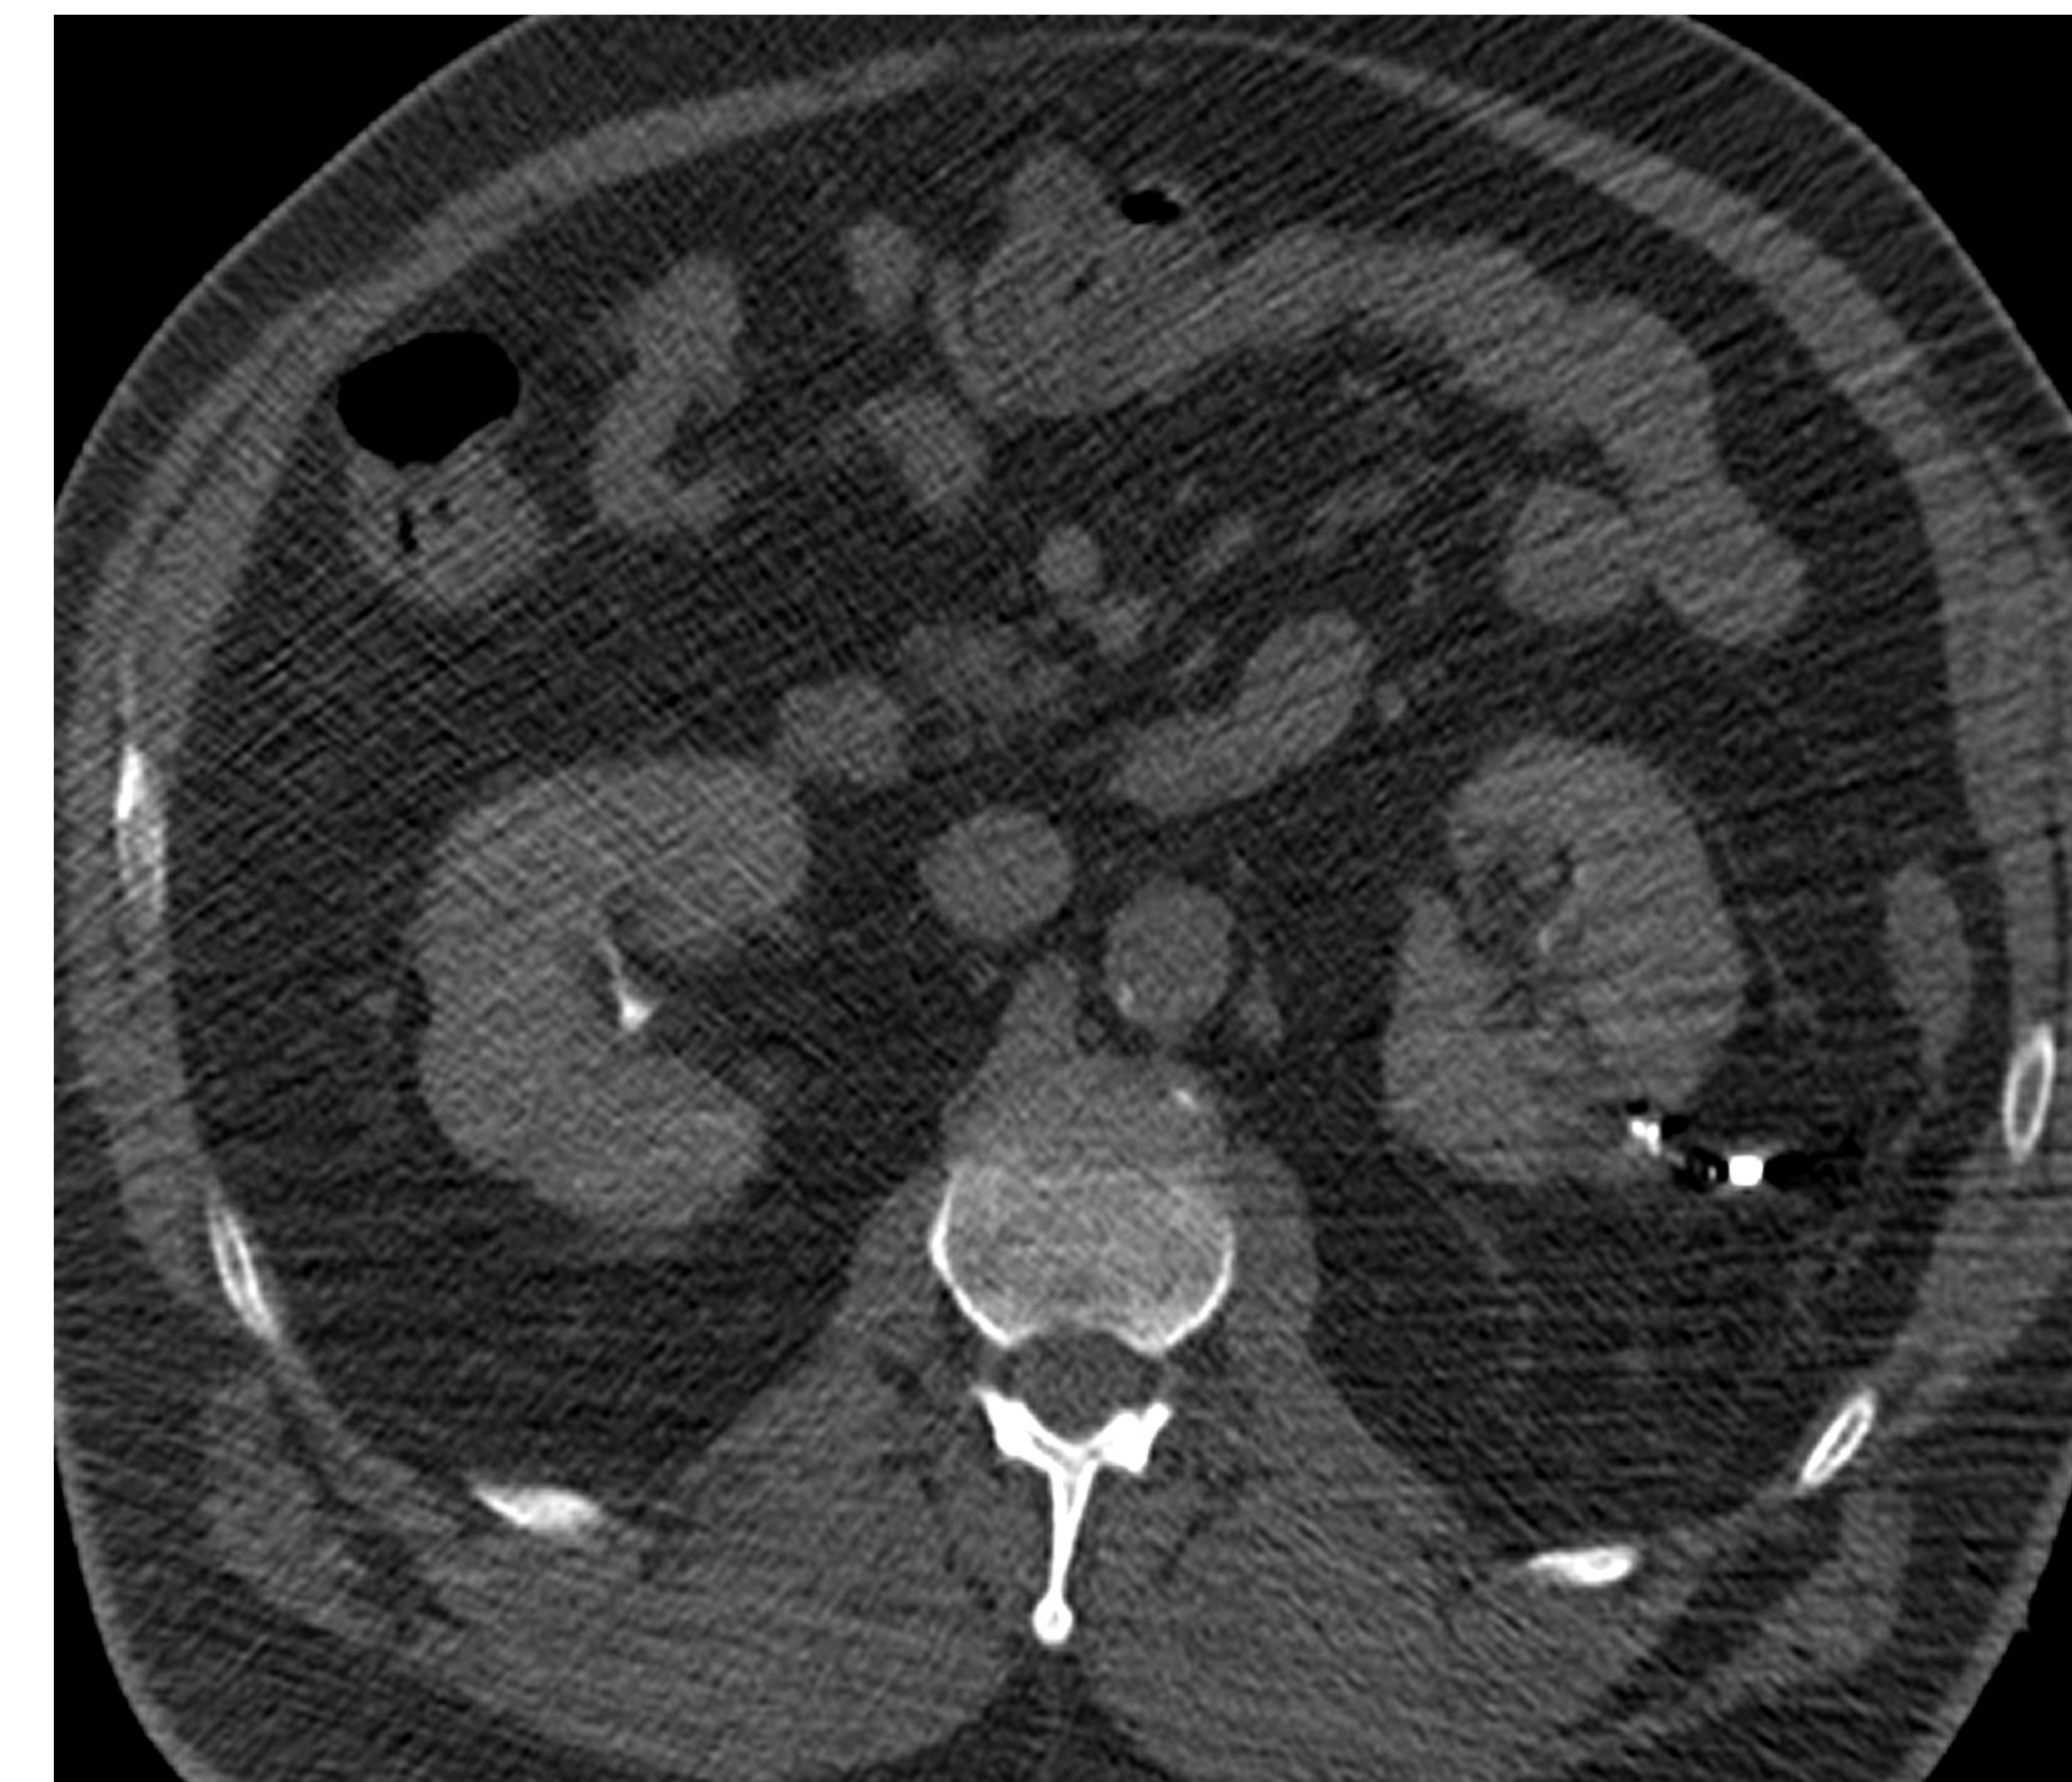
Post-procedural axial unenhanced CT demonstrates metallic fragments adjacent to the ablation site.
